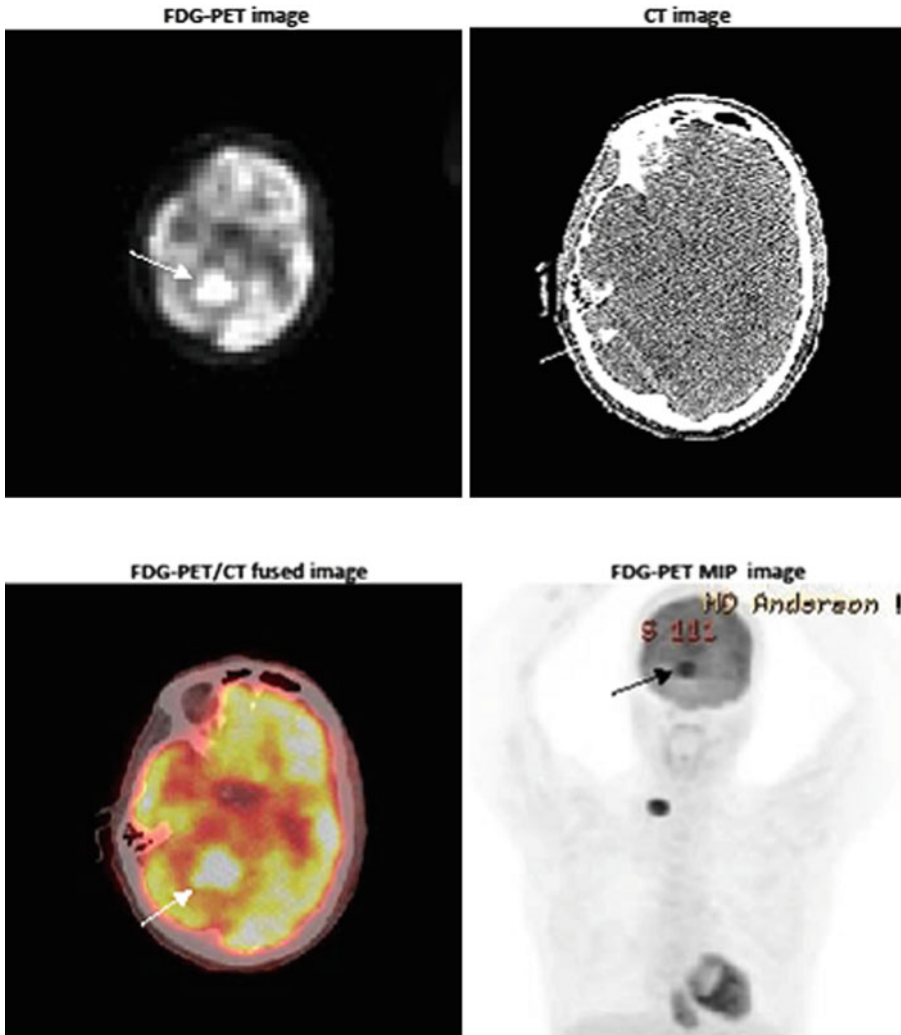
^{18}F -FDG PET/CT images of a patient with metastatic esophageal cancer. FDG-PET image demonstrates a focal hypermetabolism in right occipital lobe (arrow). On noncontrast CT images, edematous changes
